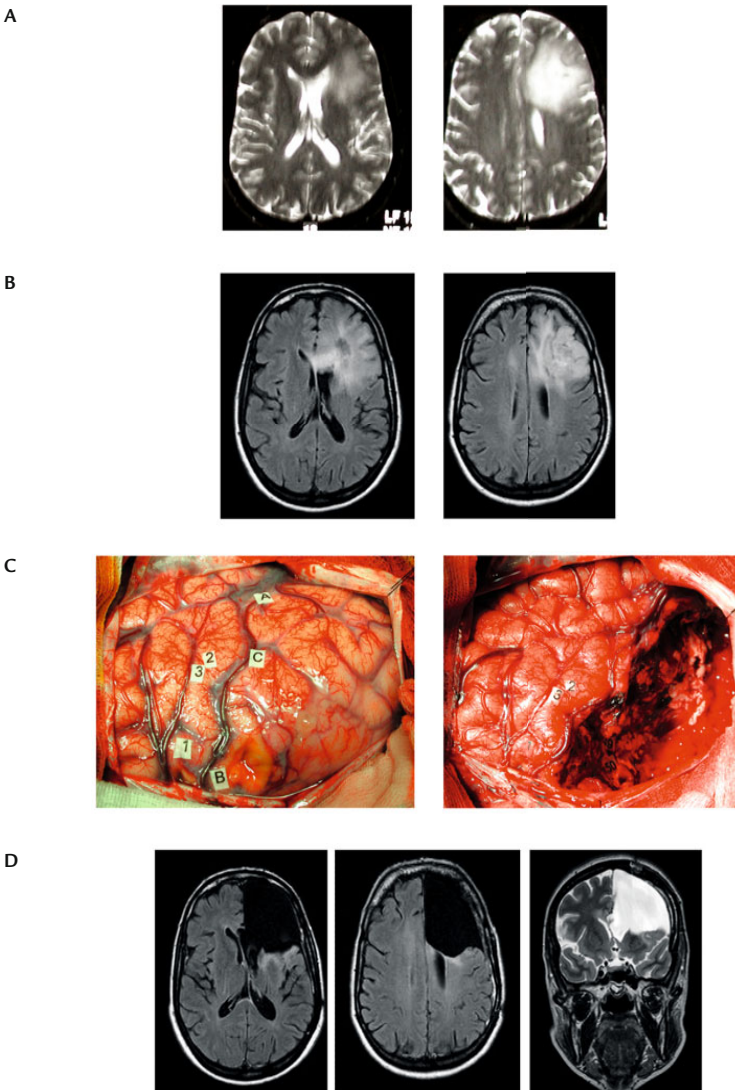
(A) Axial T2-weighted MRI in a right-handed young patient with inaugural seizures. No oncological treatment was administered. (B) Axial FLAIR-weighted MRI four years later. The patient met several neurosurgeons who said that the tumor was stable and impossible to operate due to the invasion of Broca's area. In fact, volumetric measurement showed that the tumor had doubled, then with an involvement of the corpus callosum. An awake surgery was thus proposed at our institution. (C) Intraoperative views before (*left*) and after (*right*) glioma resection delineated by letter tags. Intraoperative electrical mapping showed a reshaping of the eloquent maps within the precentral gyrus (1–3), with a recruitment of perilesional language sites located behind the glioma. There was no crucial site within the left inferior frontal gyrus. Thus, an extensive resection of Broca's area was possible and the subcortical connectivity in the depth of the cavity (49 and 50, corresponding to language pathways) was preserved. (D) Postoperative axial FLAIR- and coronal T2-weighted MRI demonstrating a near-complete resection of the glioma with removal of the corpus callosum, in a patient with neither neurological nor neurocognitive deficit, leading a normal socio-professional life. It is worth noting that a FLAIR-hyperintensity is visible in the depth of the cavity, i.e., within the deep gray nuclei and white matter tracts, still functional (Reproduced from [11])
